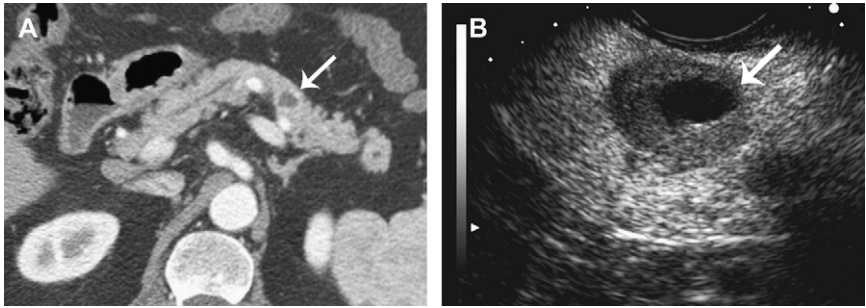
Sixty-six-year-old man who has a cystic islet cell tumor. (A) Contrast-enhanced CT shows a small mass (arrow) in the pancreatic body that is mostly cystic, with a briskly enhancing wall. (B) EUS confirms the small mass (arrow) with a central cystic space and a thicker wall than was evident on CT.
